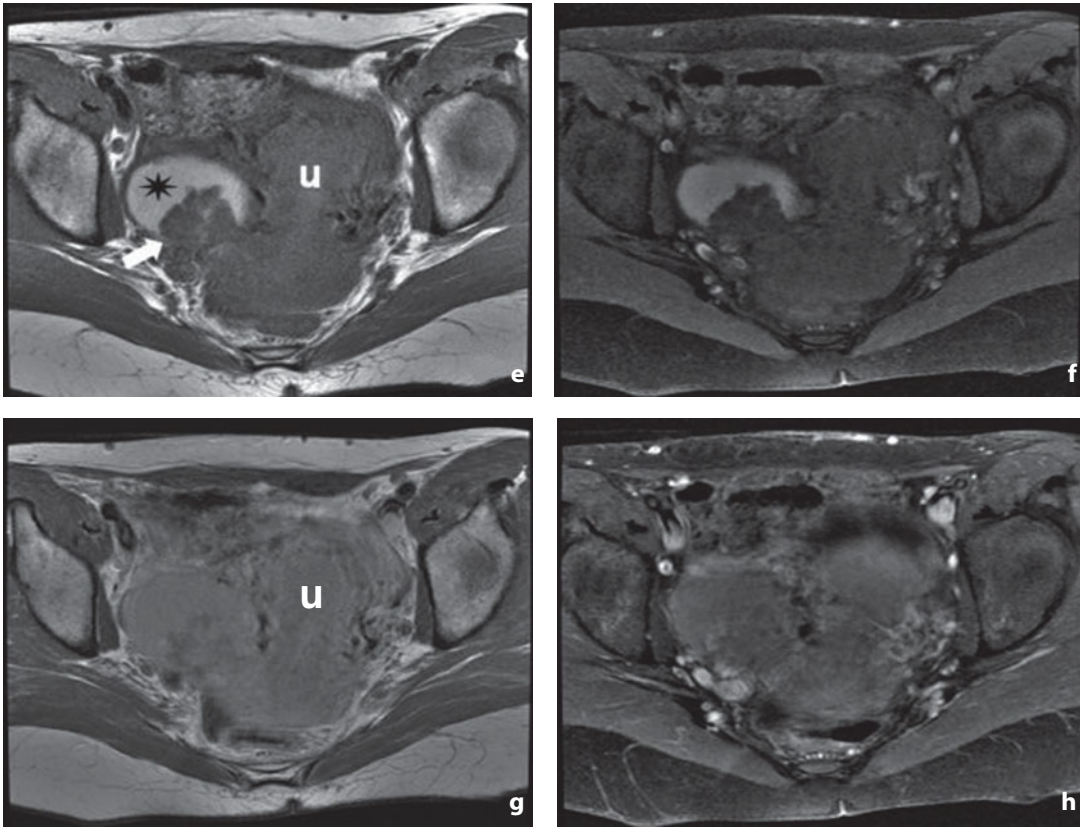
(cont.) d In the axial T2-weighted image the fluid component (*asterisk*) appears hyperintense, whereas the solid components are hypointense. In the axial T1-weighted images without (e) and with (f) fat saturation, the fluid component (*asterisk*) maintains its hyperintense signal and the solid components (*arrow*) remain hypointense. In the axial T1-weighted images without (g) and with fat saturation after contrast medium administration (h) minimal enhancement can be seen prevalently in the peripheral portion of the solid components. *U*, uterus
